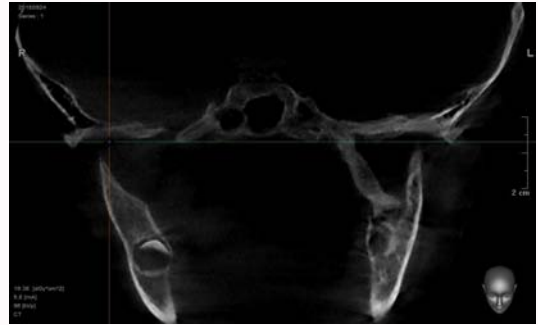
Coronal view of CT showing calcification extend through the whole body of left sphenomandibular ligament.
